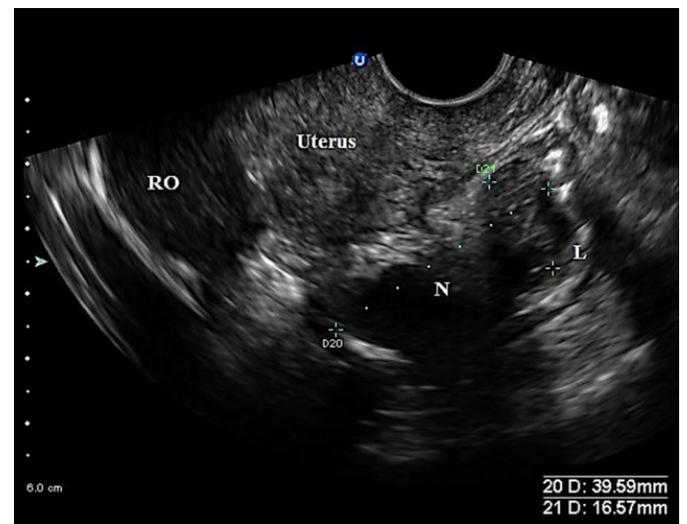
Transvaginal ultrasound image (sagittal plane) demonstrating a right ovarian endometrioma with a co-existing deep infiltrating endometriotic nodule (N) of the rectosigmoid bowel
